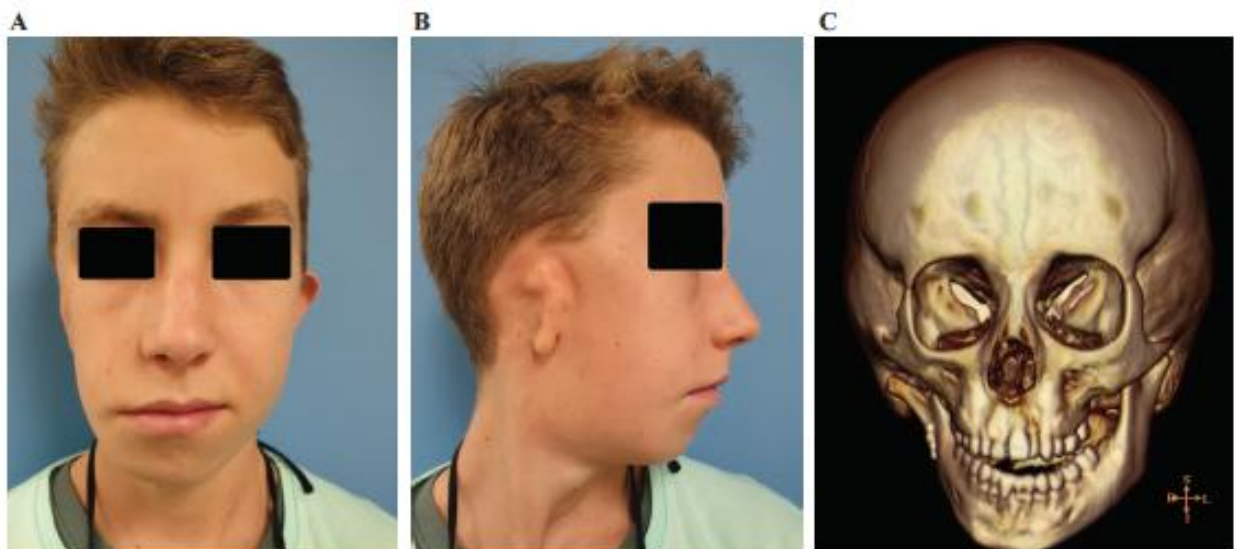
Characteristic features of hemifacial microsomia (HFM) presentation in a 15-year-old patient based on OMENS classification. (A) A frontal view of the face shows a right-sided HFM with marked facial nerve palsy, ear, and lower jaw deformities. (B) Lateral view showing remnant ear lobule and retrognathia. (C) A 3D reconstructed CT showing deformed mandible (M2B) and malocclusion class III with marked facial asymmetry. The OMENS classification is O1M2BE3N3S1.
